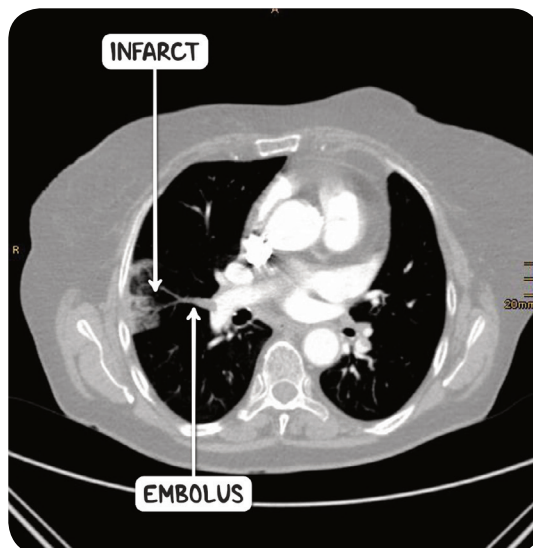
A CT pulmonary angiogram demonstrating a pulmonary embolus and subsequent right middle lobe infarct.
